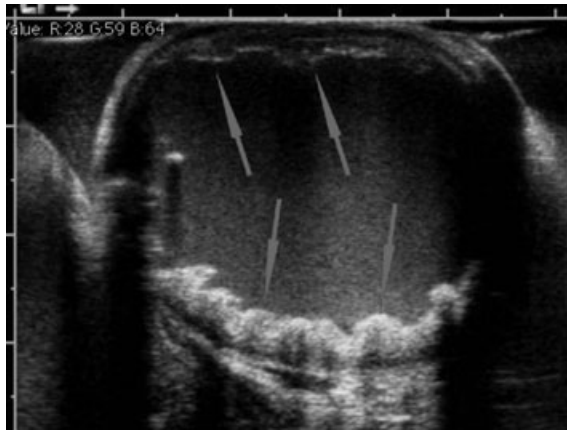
Epiaortic ultrasonography showing ascending aorta. Arrows show atherosclerotic plaques.
